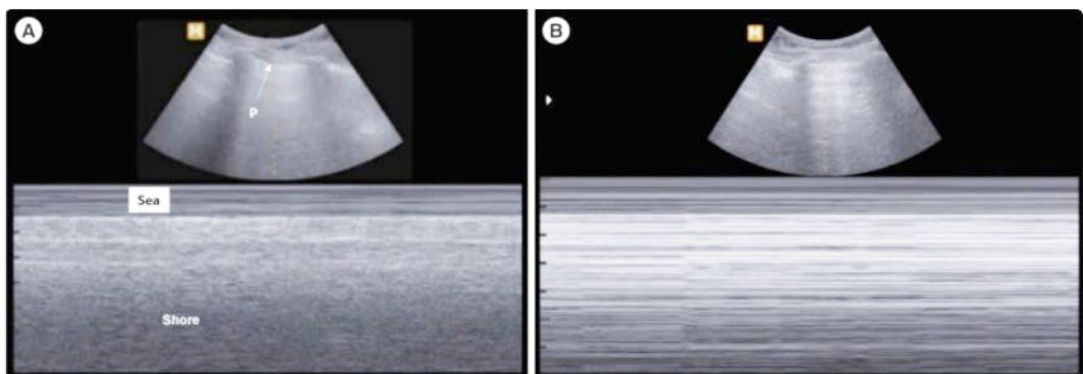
M-mode lung ultrasound. (A) Normal lung with sea-shore sign in M-mode. P indicates the pleural line. (B) Pneumothorax with the barcode sign in M-mode indicating no movement below the pleural line. (adapted from Choi et al, 2023)
